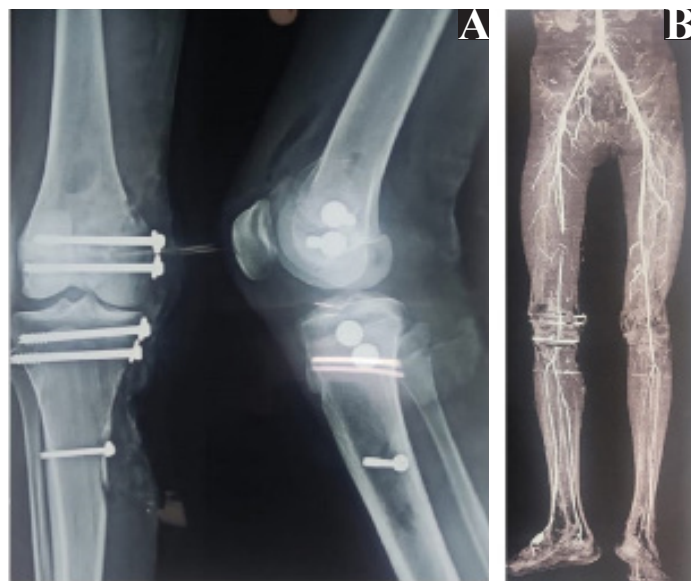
A. X-ray of the right knee joint showing cancellous screw fixation for fracture of medial condyle of femur and tibial plateau fracture; B. CT angiography of the right lower limb showing a lack of contrast opacification in segment of the superficial femoral artery in the mid thigh
